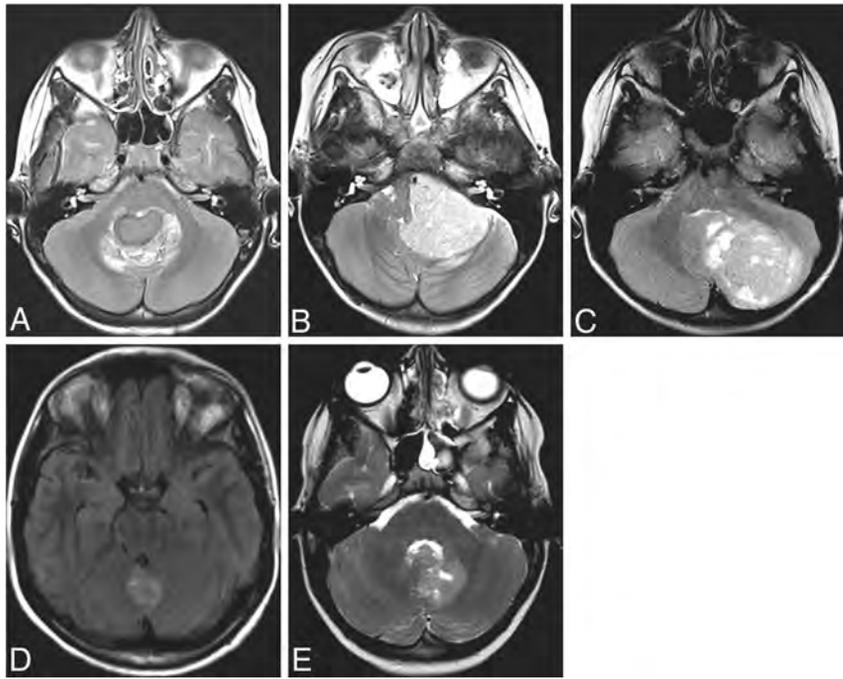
A–C, and E, T2WI. D, T2-FLAIR. Examples for primary tumor positions in WNT-MB. The midline fourth ventricle (A), cerebellopontine angle (B), cerebellar hemisphere (C), midline cerebellar vermis (D), and periventricular deep white matter (E).
